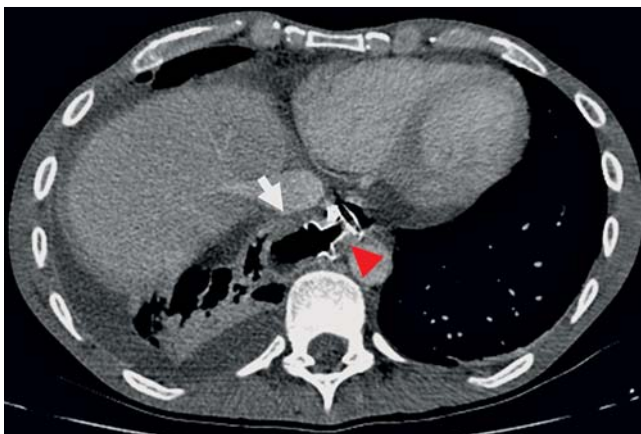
Follow-up computed tomography (CT) scan after 7 days showing the AXIOS stent (arrowhead) still in place with significant resolution of the lesion (arrow).
